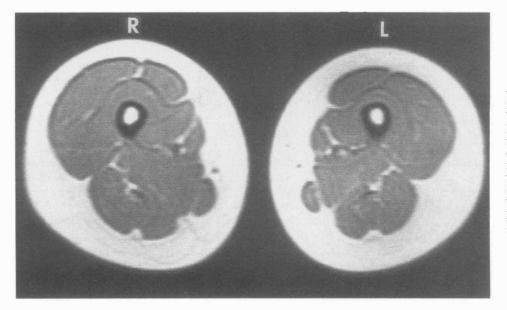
Representative single-echo transaxial proton magnetic resonance image of both thighs collected in whole body coil after 6 wk of unilateral lower limb suspension (repetition time/echo time 2,000/20,  $256 \times 256/2.0$  number of exitation, field of view 40 cm, and thickness 10 mm). View is horizontal plane through both thighs looking proximal. Substantially smaller muscle cross-sectional area appears in subject's left (L) suspended thigh (appears on viewer's right). R, right.
